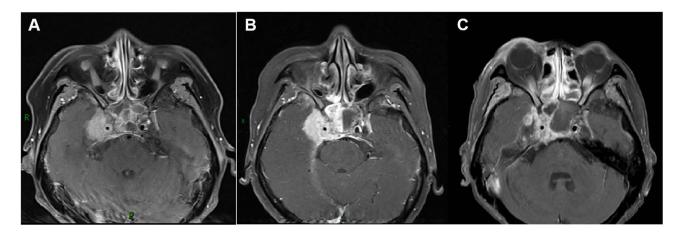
Figure I MRI scan of the patient experiencing nasopharyngeal progression after neoadjuvant therapy. (A) The baseline of the tumor. (B) Tumor progression after neoadjuvant therapy. (C) Partial remission of the tumor after IMRT.
